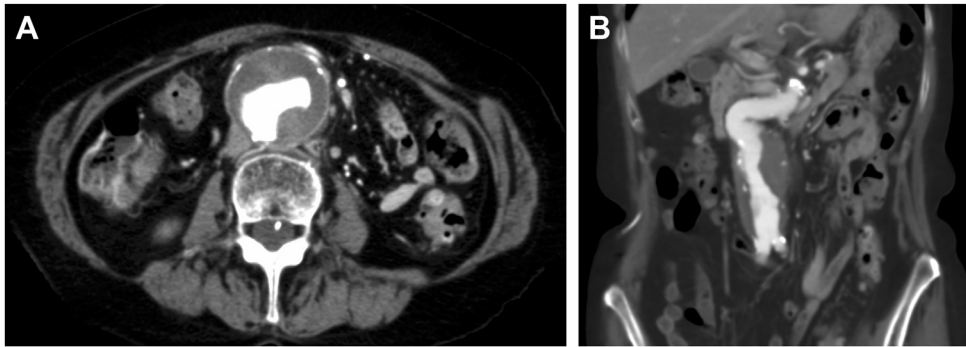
Preoperative computed tomography: (A) axial and (B) coronal.
